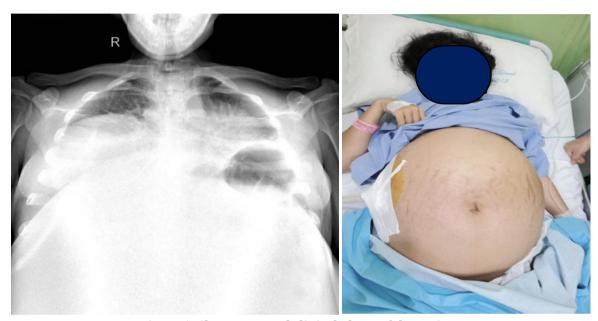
Chest x-ray and clinical photo of the patient
